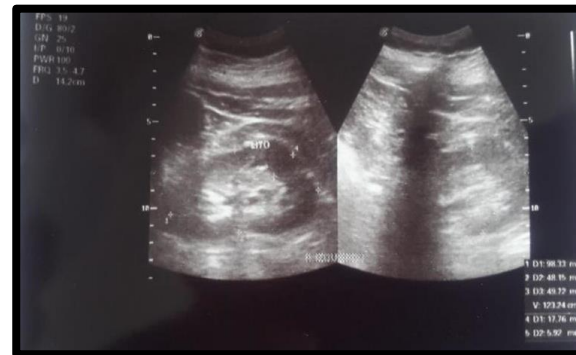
Ultrasound prior to lithotripsy and initiation of metabolic treatment for lithiasis, the presence of kidney stones in lower and middle calyces is observed. Top image: right kidney, bottom: left kidney..
